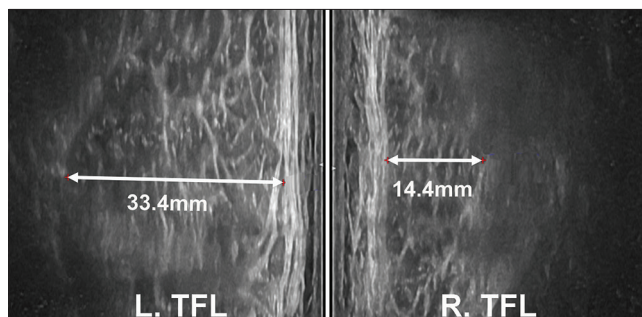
High-resolution ultrasound images revealed a greater width of the tensor fascia lata muscle on the left (33.4 mm) compared to the right (14.4 mm) side.
